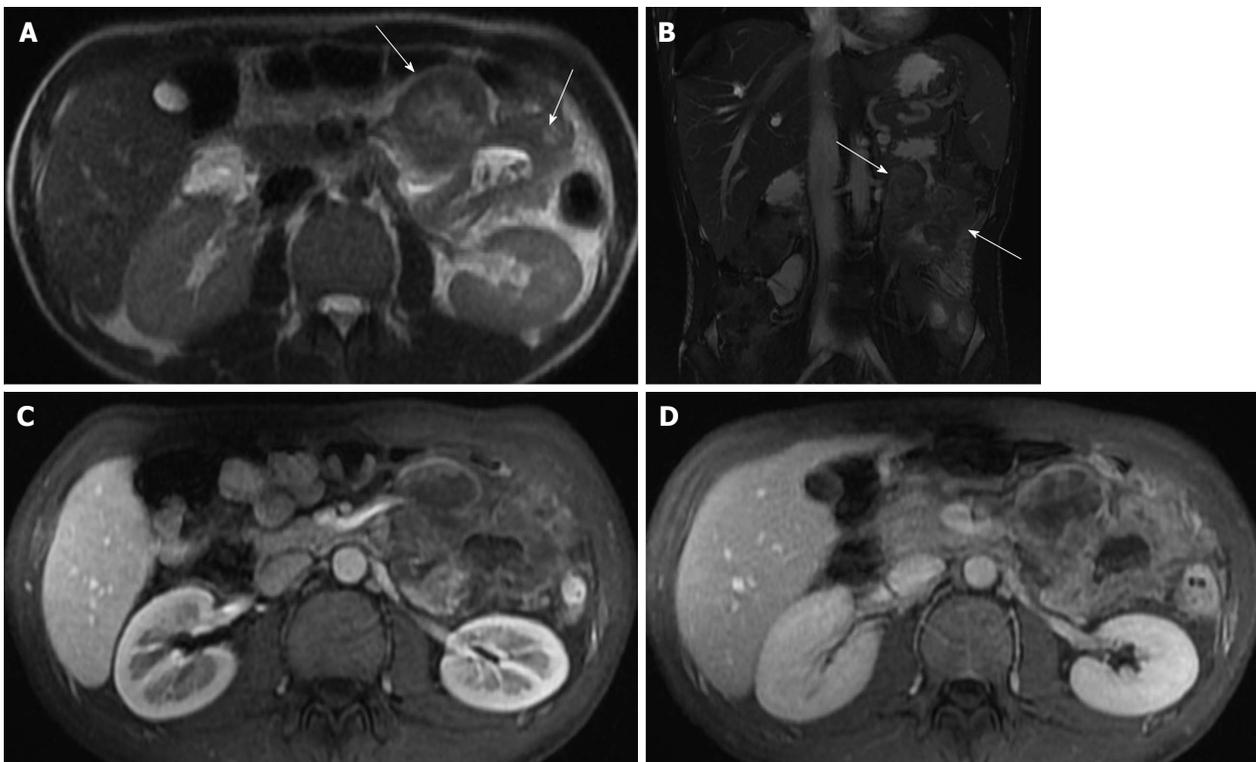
Jejunal adenocarcinoma. A: Axial T2-weighted single shot fast spin echo and (B) coronal balanced steady state free precession images as well as axial fat-suppressed post-gadolinium 3D-GRE T1-weighted images during the (C) hepatic arterial dominant and (D) hepatic venous phases. There is significant circumferential, irregular, asymmetric wall thickening of the proximal jejunum with exophytic extension (arrows, A and B) and hypovascular enhancement pattern (C and D) in keeping with a pathologically proven jejunal adenocarcinoma. GRE: Gradient recalled echo.
